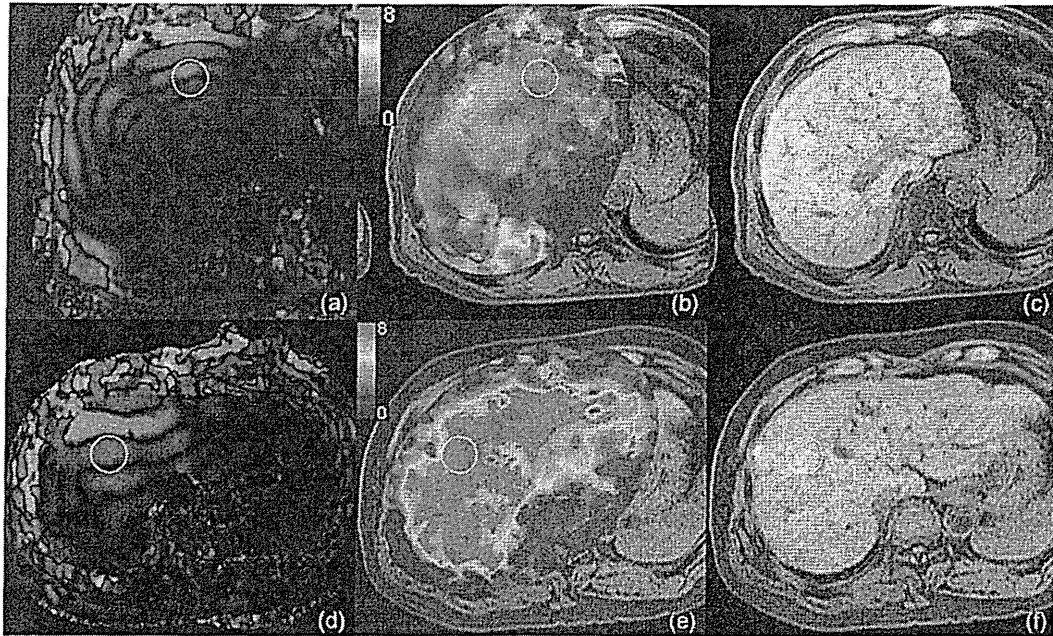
Magnetic resonance elastography (MRE) images of 2 patients, (a-c) a 62-year-old man with mild fibrosis (F1) and (d-f) a 58-year-old man with cirrhosis (F4). (a & d) Phase images; (b & e) portions of the elastogram that correspond with the liver superimposed on conventional MR images; (c & f) magnitude images. A region of interest (ROI) was placed in the right lobe of the liver (circle) based on the criteria that the ROI was at least 1.5 cm², excluded blood vessels seen on the magnitude image of MRE, excluded the edge of the liver, and included a parallel wave form without interference on the phase images. The mean liver stiffness values increased with the progression of the stage of fibrosis.
